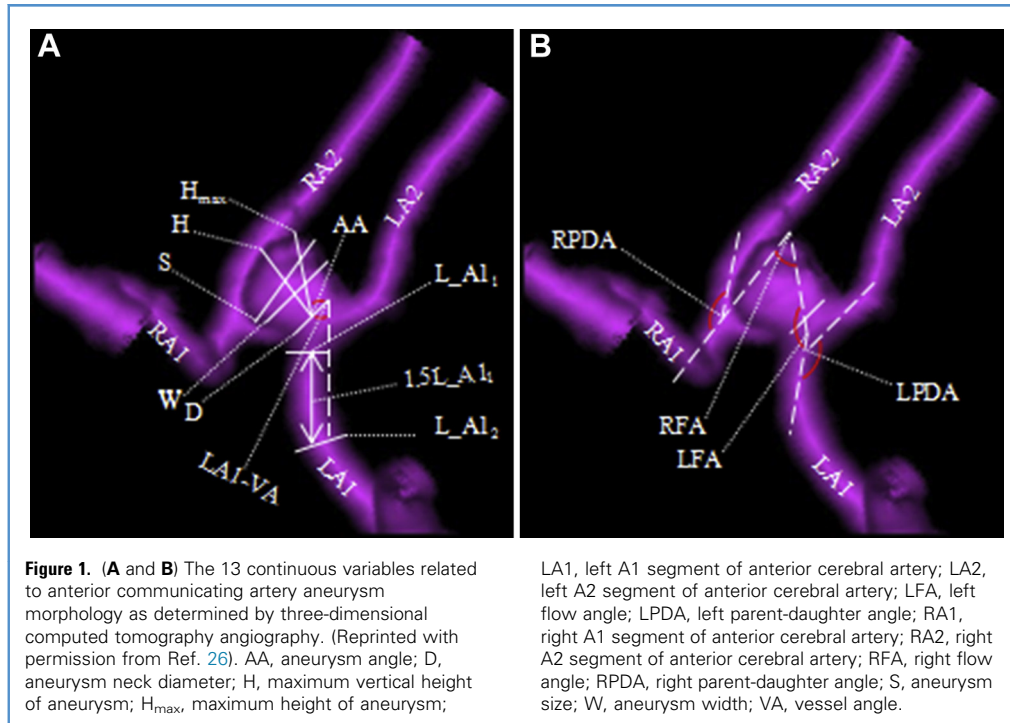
(A and B) The 13 continuous variables related to anterior communicating artery aneurysm morphology as determined by three-dimensional computed tomography angiography. (Reprinted with permission from Ref. 26). AA, aneurysm angle; D, aneurysm neck diameter; H, maximum vertical height of aneurysm; H_{max} , maximum height of aneurysm;
